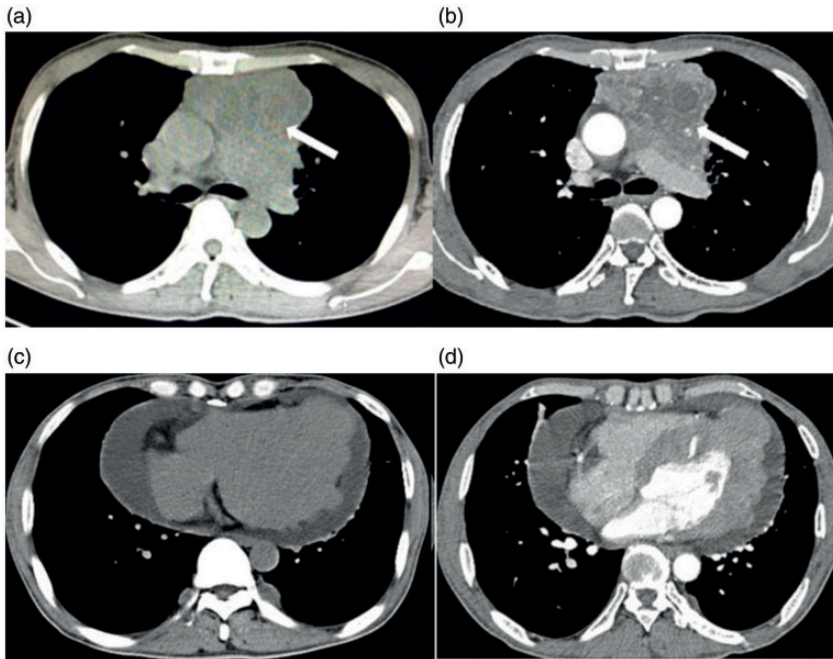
(a) Chest computed tomography showed an irregular soft tissue density in the anterior mediastinum. (b) Contrast-enhanced chest computed tomography showed non-uniform enhancement of the mass, with low-density necrotic foci and chaotic blood vessels. (c) Unenhanced and (d) enhanced computed tomography slices of the cardiac ventricle.
